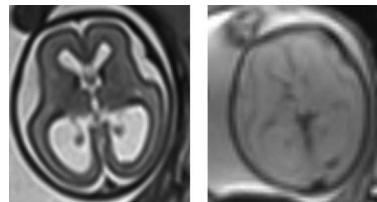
Severe ventriculomegaly, gestational age 24 weeks: small blood remnant adherent to the posterior wall of the occipital horn of the left lateral ventricle, barely detectable on the standard T2-weighted images (left), but clearly visible as a black spot on the dedicated sequence on the right.
